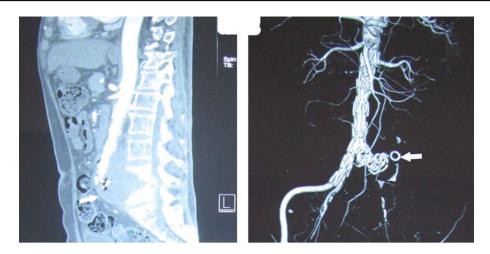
CTA 7 days after EVAR demonstrating a successfully sealed orifice of the aneurysm (white arrow in right figure), and the aneurysm had thrombogenesis (white arrow in left figure).
